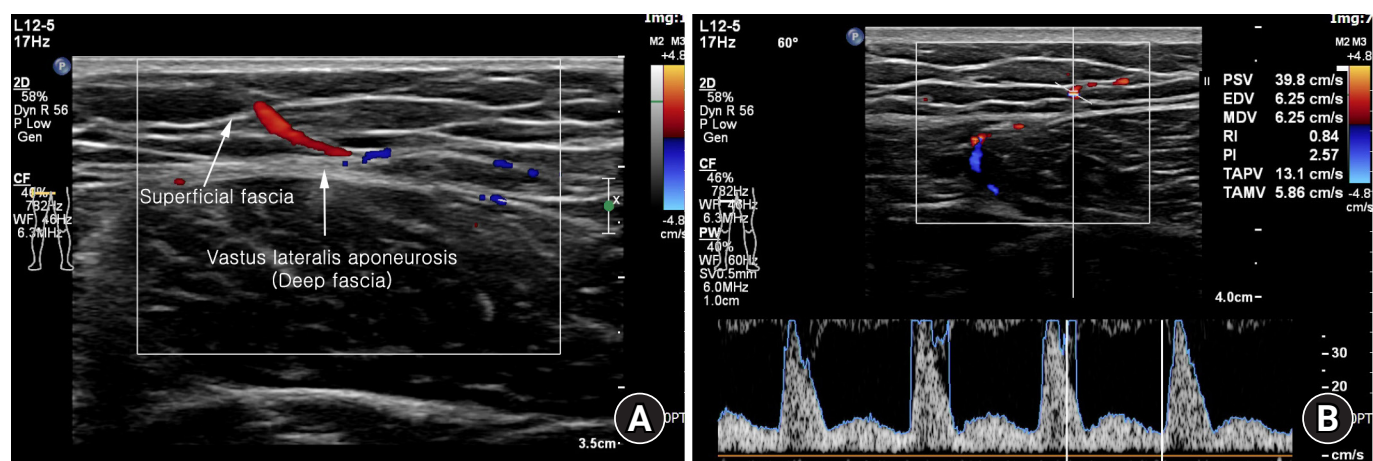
Color Doppler ultrasound preoperative assessment (perforator 33). (A) The location and course of the perforator surges through the superficial fascia (left arrow) from the vastus lateralis aponeurosis (deep fascia, right arrow). (B) The flow of the perforator is measured using the color Doppler flowmeter.
